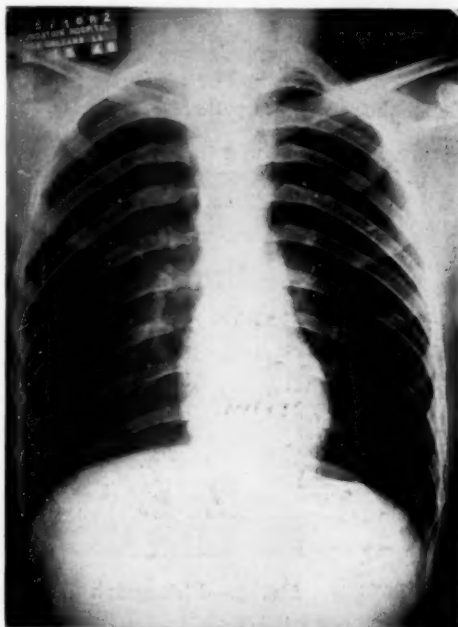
Roentgenogram of the chest taken five weeks after the accident shows normal heart and lungs and no cardiac dilatation. No change is seen from roentgenogram made two weeks previously.
